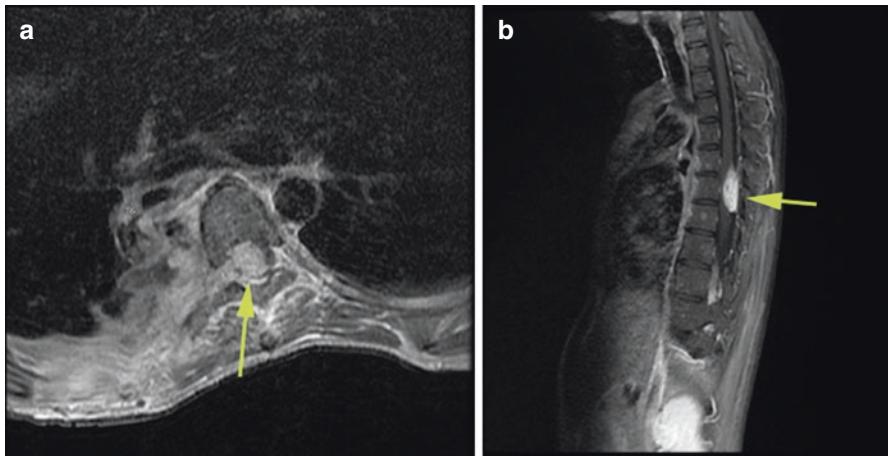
(a, b) T1-weighted axial and sagittal series showing resection of the giant right intrathoracic malignant nerve sheath tumor with both extraforaminal as well as intraspinal extradural recurrence compressing the spinal cord
